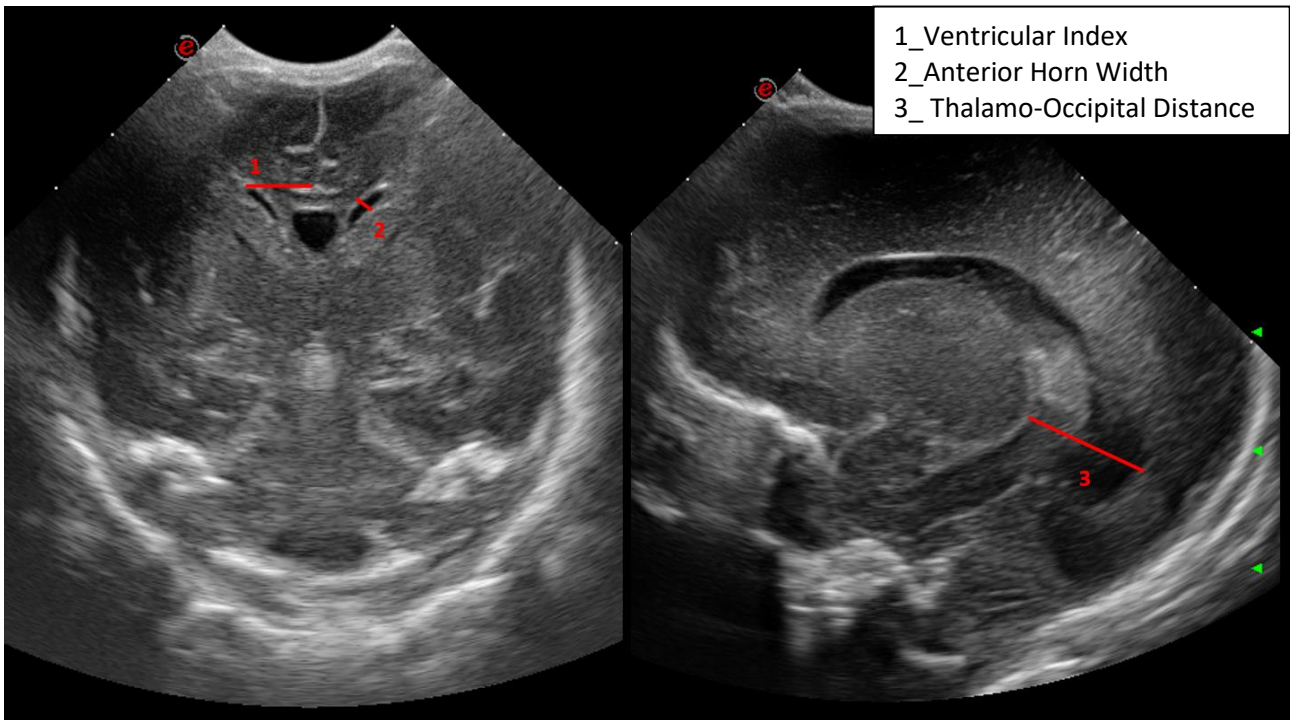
PHVD ultrasound normal measurement.
